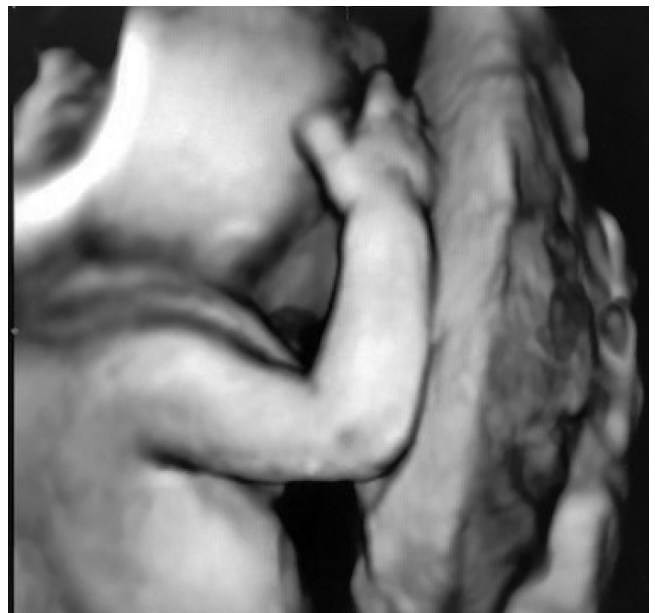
4D Ultrasound of the Baby
